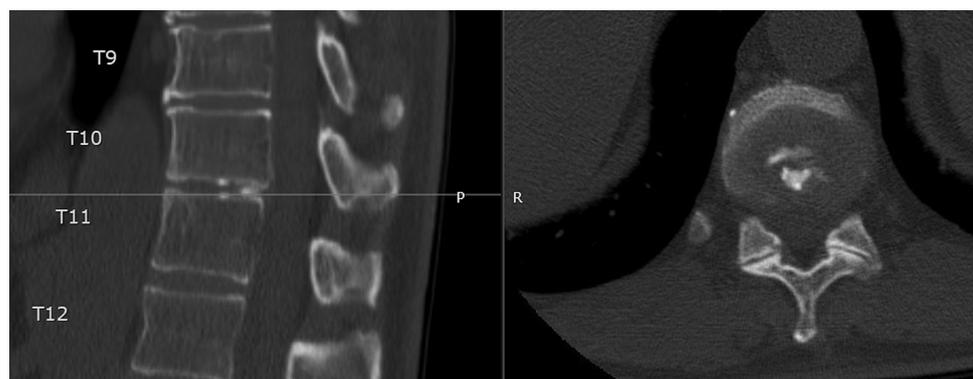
CT scan revealing spontaneous resolution of lesion at T10–T11.
